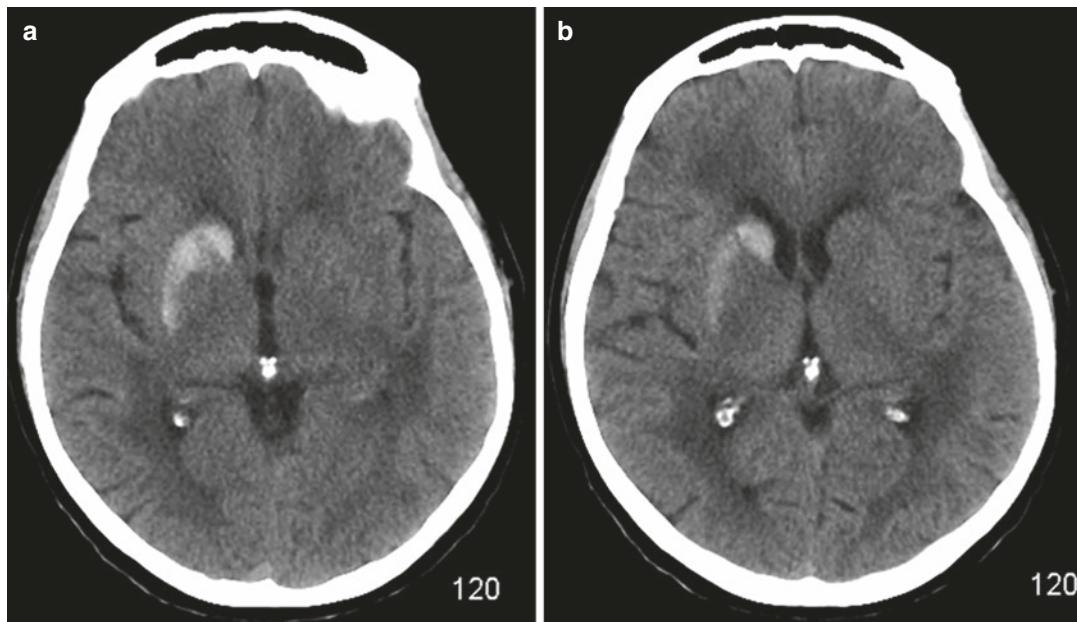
Nonketotic hyperglycemia hemichorea-hemiballismus. Axial non-contrast head CT (a, b) shows parenchymal hyperdensity involving the head of the right
